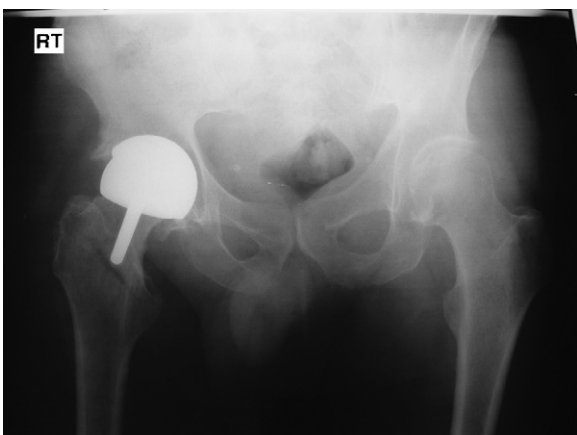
Patient 2 radiograph AP pelvis at presentation.
